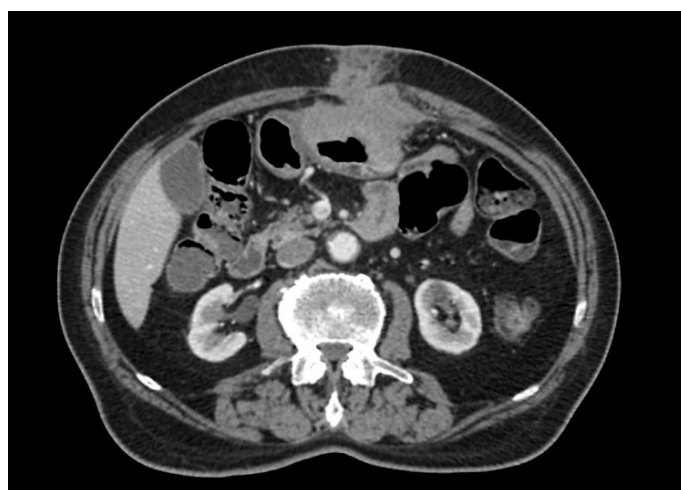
Computed tomography image of the mass that extends into the corpus of the stomach
